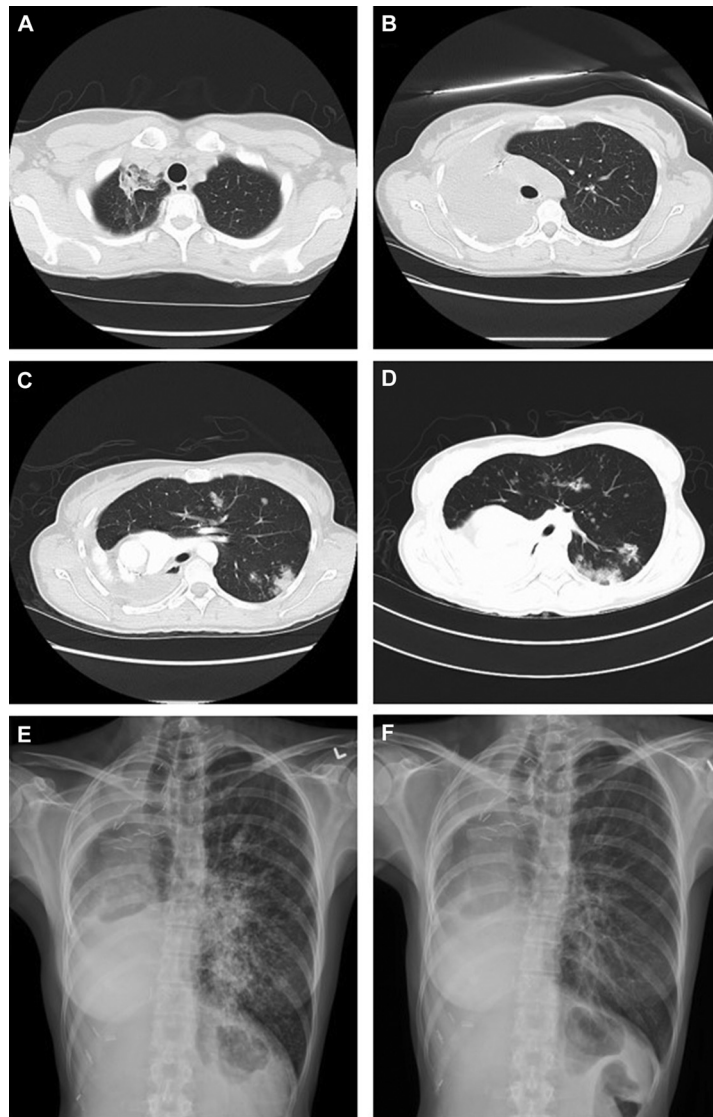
Medical imaging. (A) Computed tomography (CT) scan (November 2012) with a right upper lobe lung mass after 4 months of gefitinib treatment (partial response). Before right pneumonectomy. (B) CTscan (September 2013) after right pneumonectomy and before restarting gefitinib. Interval development of multiple small nodules in the left lung. (C) CT scan (August 2015) before start osimertinib. Multiple small and intermediate size nodules in left lung. (D) CTscan (March 2017) disease progression in left lung. (E) Chest radiograph (July 2017) before start of afatinib. Coarse nodular parenchymal opacities in left lung. (F) Chest radiograph (August 2017) at 1 month on afatinib. Nearly complete reduction of the nodular parenchymal opacities in left lung.
